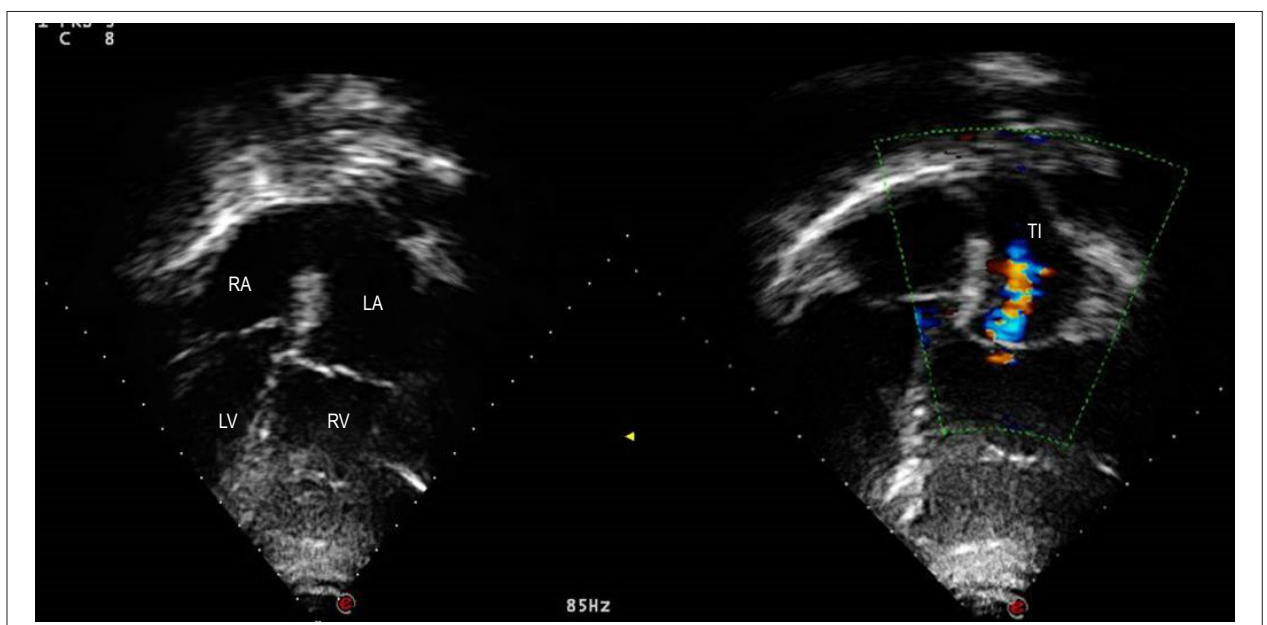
Echocardiogram shows the characteristic images of corrected transposition of the great arteries with slight right ventricle dilation on the left and mild tricuspid valve regurgitation on the left. The mitral valve on the right is upper and the tricuspid valve is lower, on the left.
